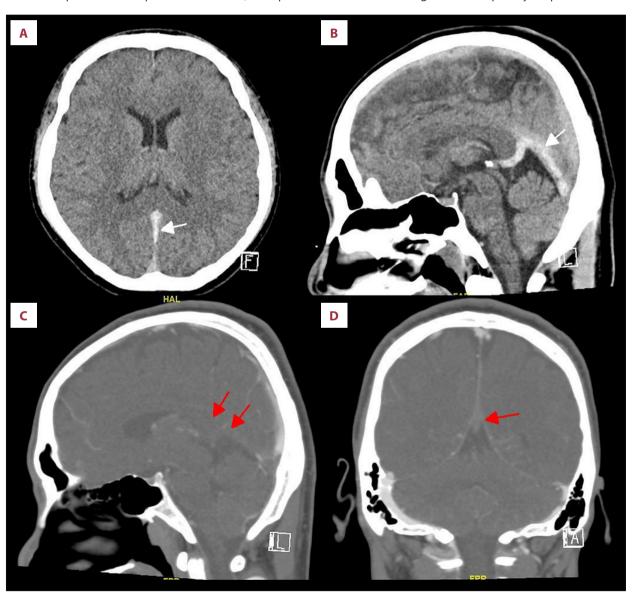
Axial (A) and sagittal (B) planes of the non-contrast-enhanced computed tomography (CT) brain show hyperdensity of the straight sinus, indicating venous sinus thrombosis (white arrows). Sagittal (C) and coronal (D) planes of CT venography show filling defects suggestive of thrombosis of the straight sinus and vein of Galen (red arrows).
